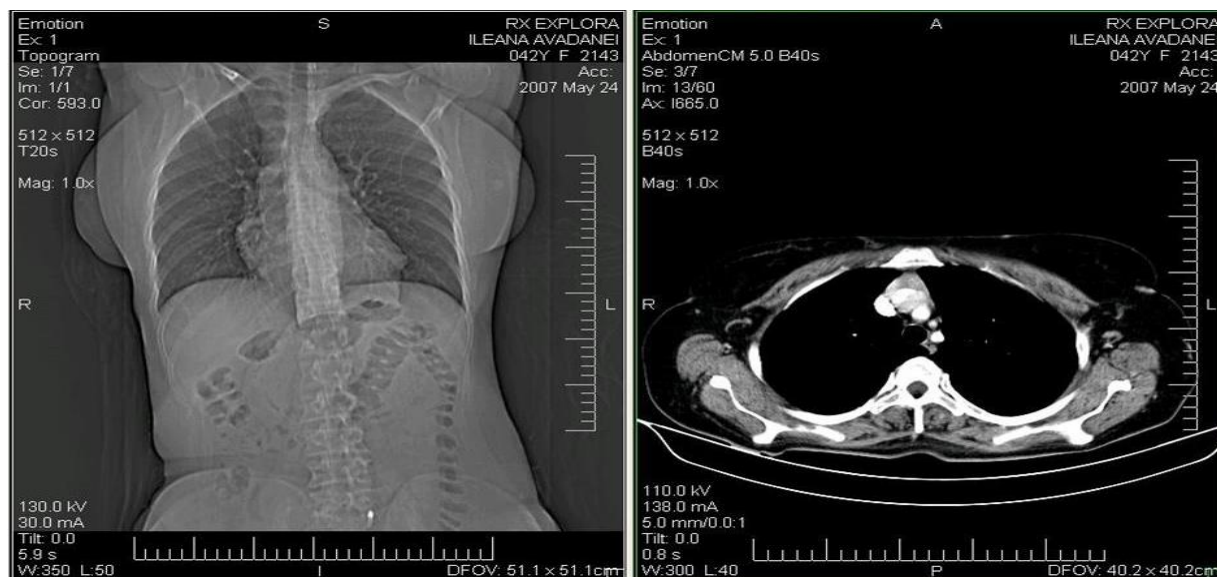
Thorax CT for thymic lymphoid hyperplasia.
